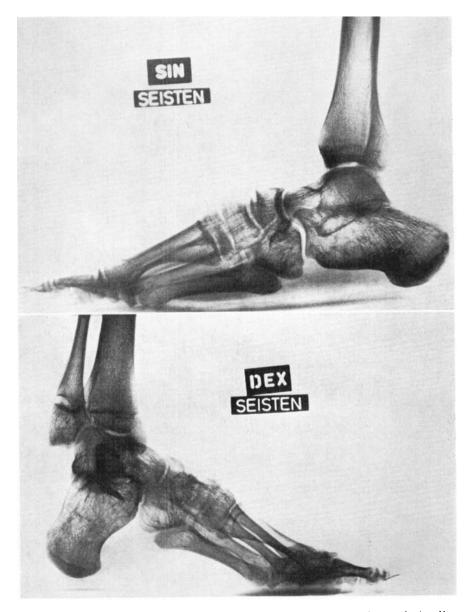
F. Roentgenograms twelve years postoperatively, in supine and standing positions (standing = seisten).
